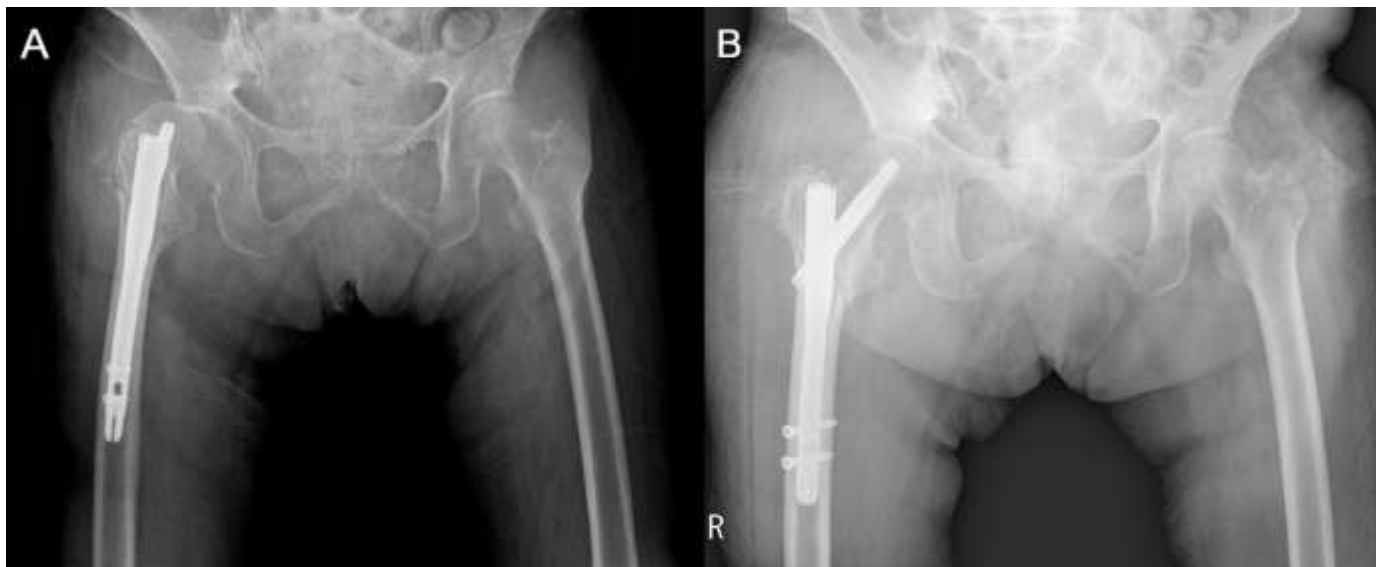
Plain radiographs show anterior recurrent dislocation of the hip joint (A) and post-reduction status by Allis maneuver (B) at postoperative weeks 14.
